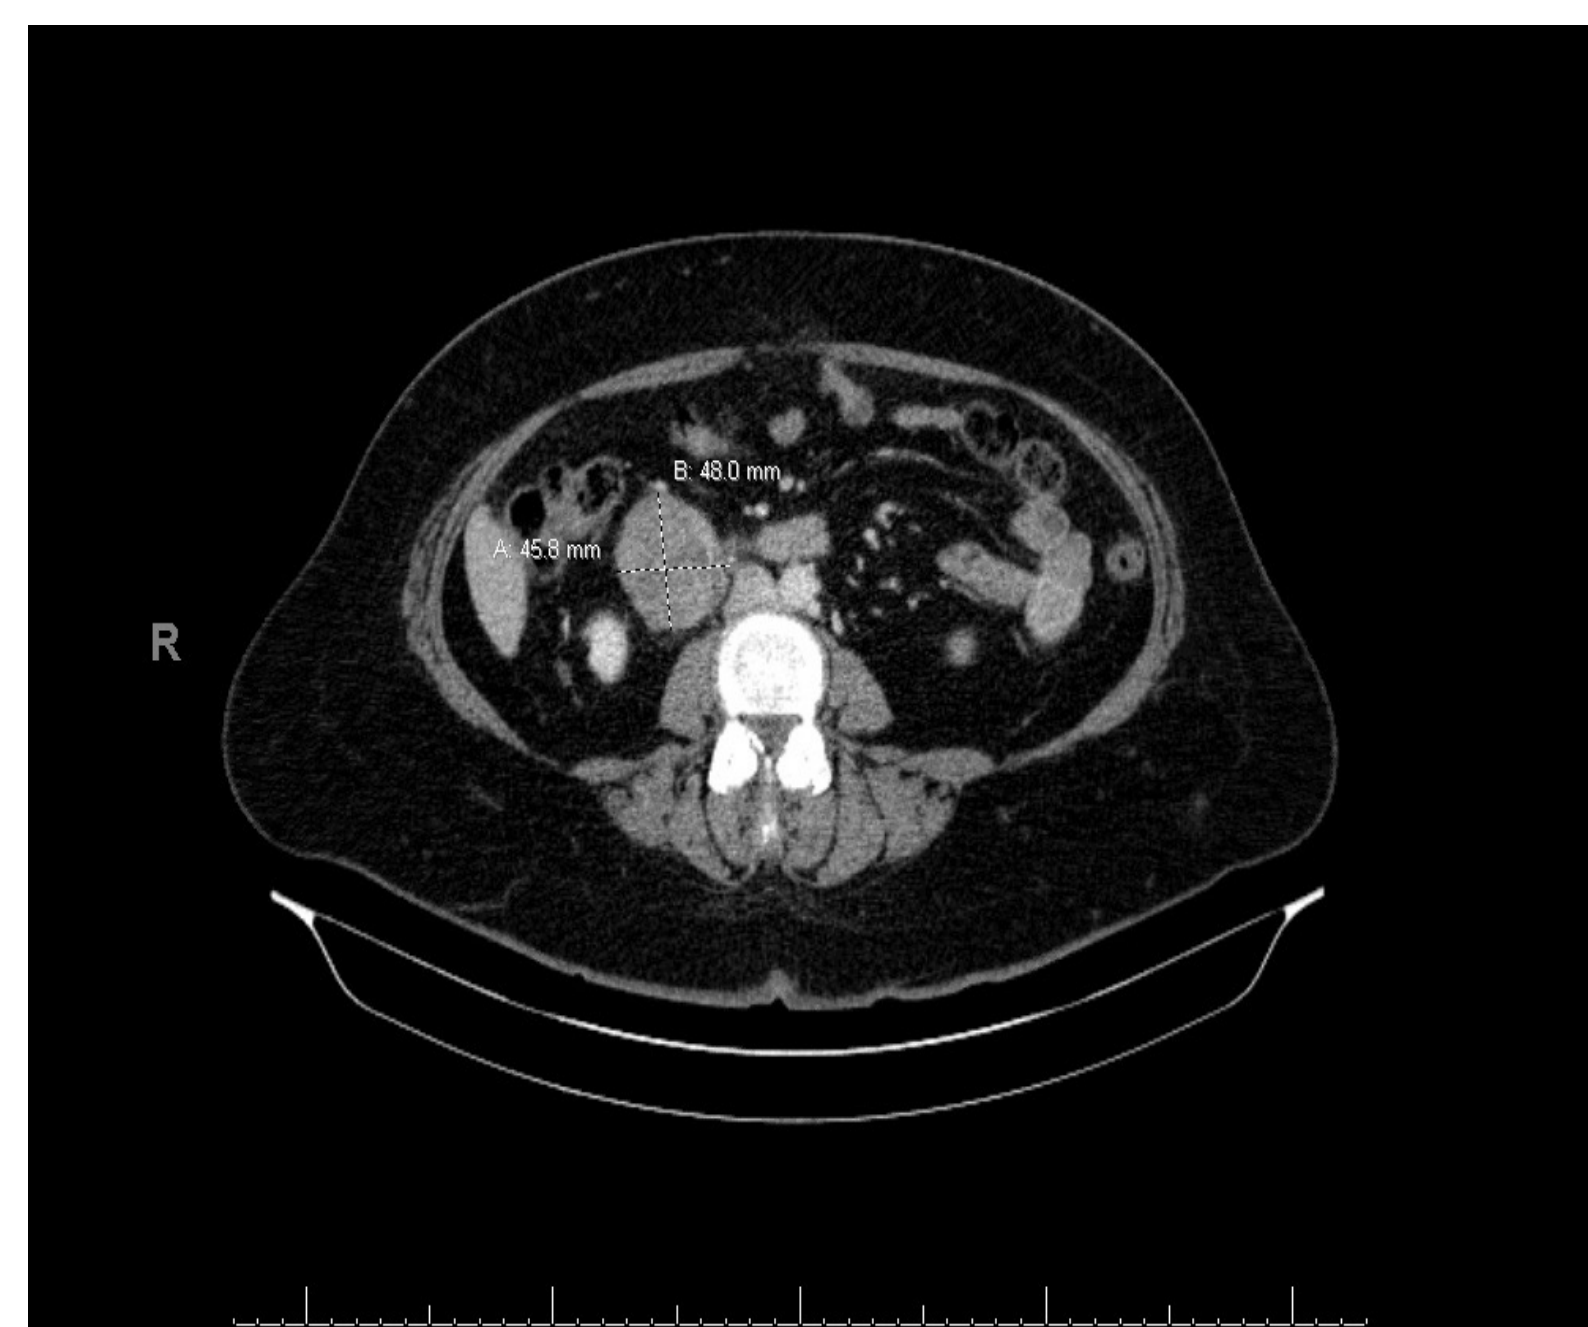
and 2) CT scan of Right Gonadal Vein Leiomyosarcoma
